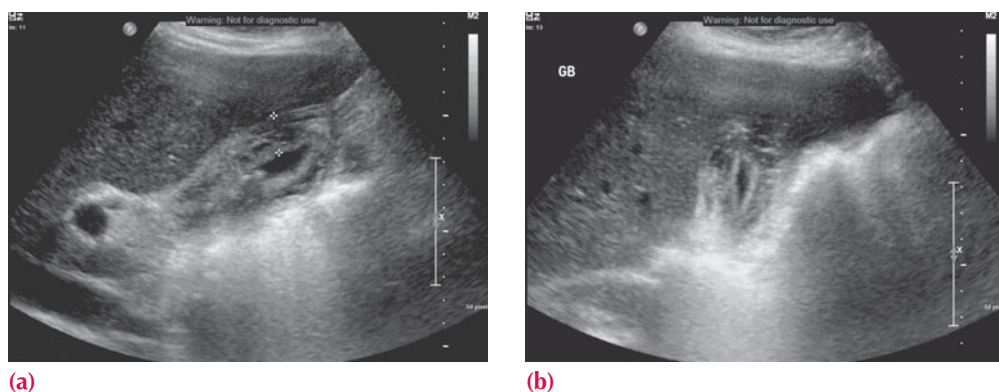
Ultrasound views of the liver and gallbladder in longitudinal (a) and transverse (b) planes.
